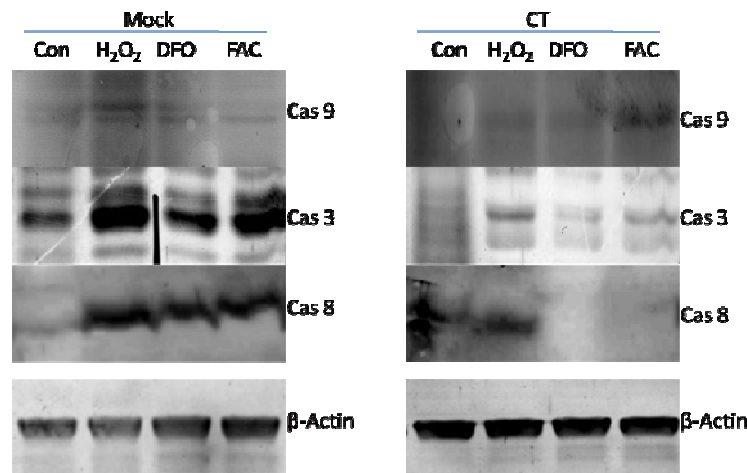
Caspase activation is regressed in CT infected cells: Immunoblot showing bands representing Caspase 9, 8 and 3.
